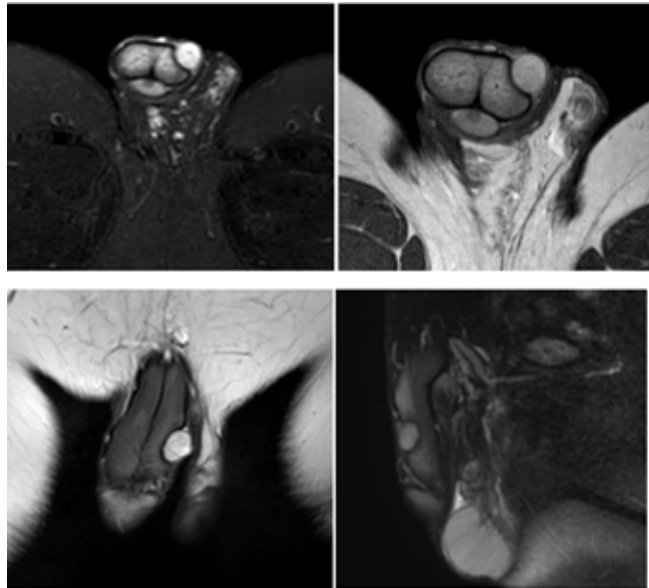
Well defined T1 hypointense and T2 STIR mixed signal intensity lesion measuring 2cm × 1.4cm in the deep fascia of dorsal nerve of penis was seen in MRI.
